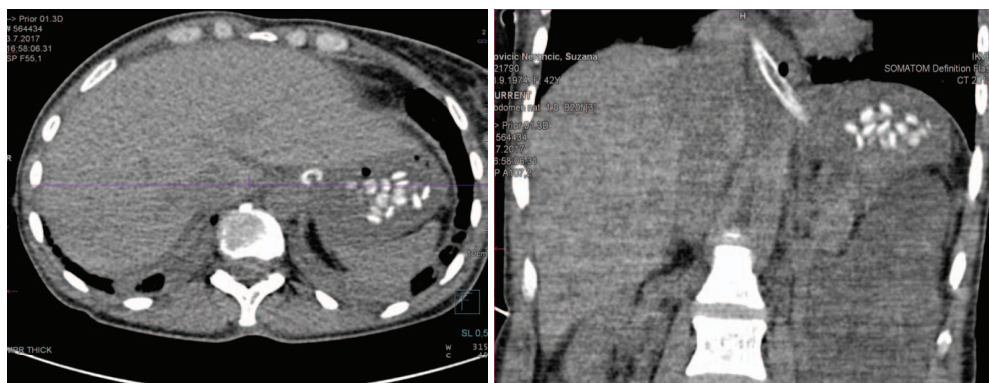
Computed tomography (CT) scan of the abdomen showing massive amount of undigested tablets in the stomach.
